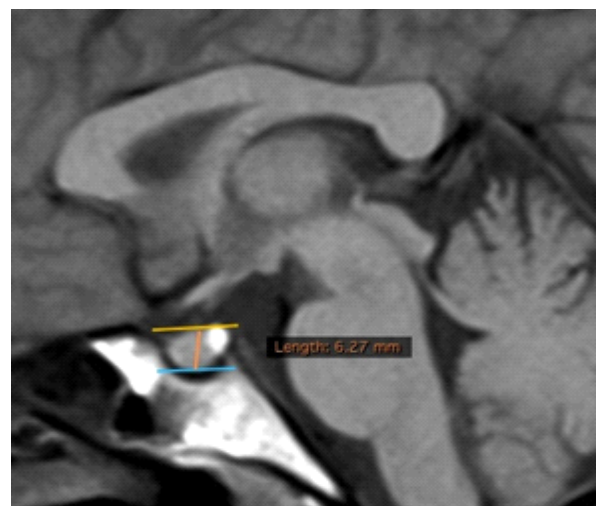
T1-weighted mid-sagittal image of pituitary gland. Vertical line shows height of gland.
